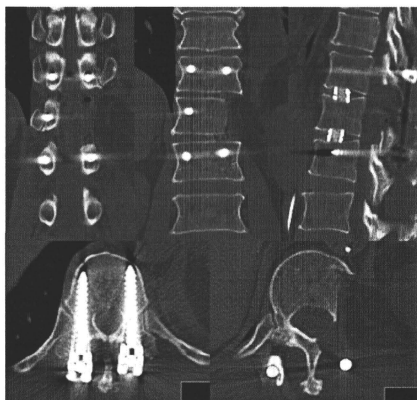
Case 1. Postoperative CT images demonstrating the precise osteotomy, *en bloc* tumor excision, and accurate pedicle screw placement.
